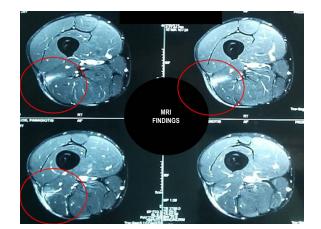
MRI findings from the site of injury.
